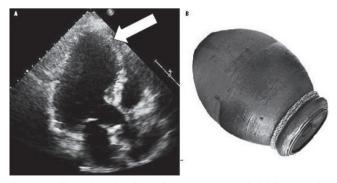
(A) Trans-thoracic echocardiogram showing apical left ventricular dysfunction. (B) A tako tsubo pot.
